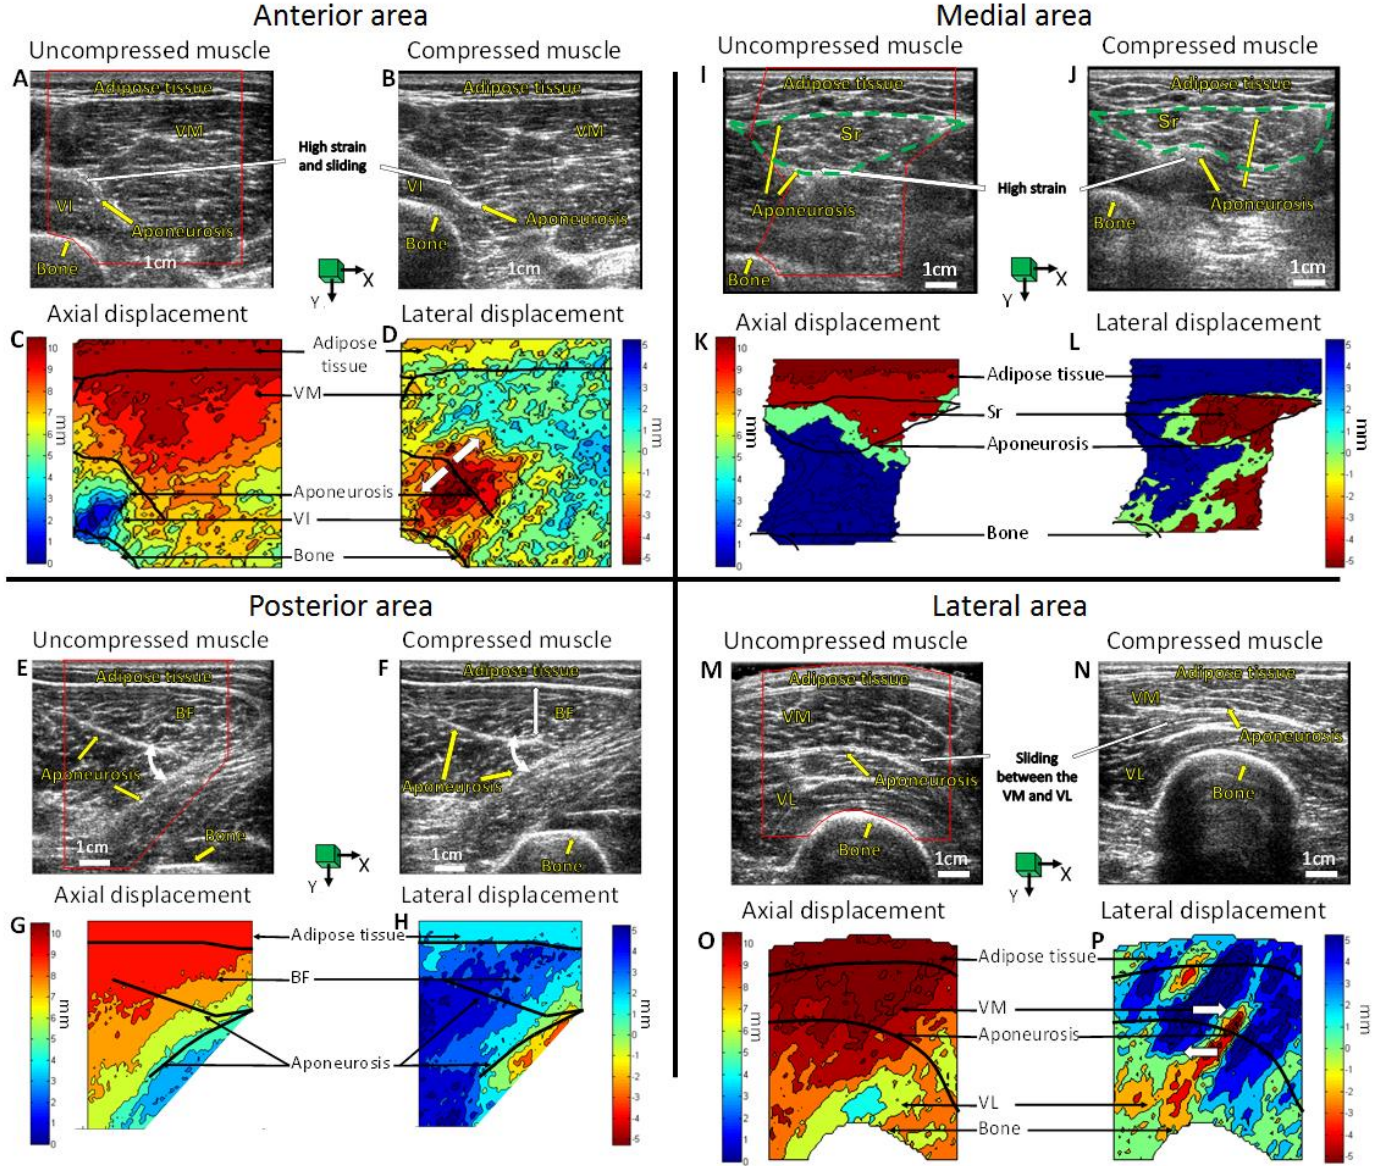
Ultrasound acquisitions on the anterior, posterior, medial and lateral areas of the thigh (A, E, I, M) in the unloaded condition and under a loading (B, F, J, N) of 1 kPa. Horizontal (C, G, K, O) and vertical displacement fields (D, H, L, P). (VM: vastus medialis, VI: vastus intermedius, Sr: sartorius, BF: biceps femoris, VL: vastus lateralis)
